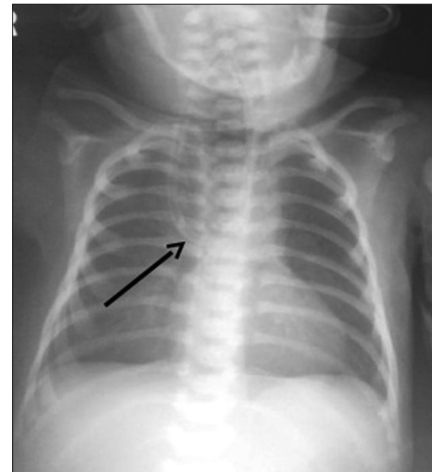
Chest radiograph of a case of oesophageal atresia with tracheo-oesophageal fistula showing coiling of feeding tube at T4-T5 level (black arrow)
